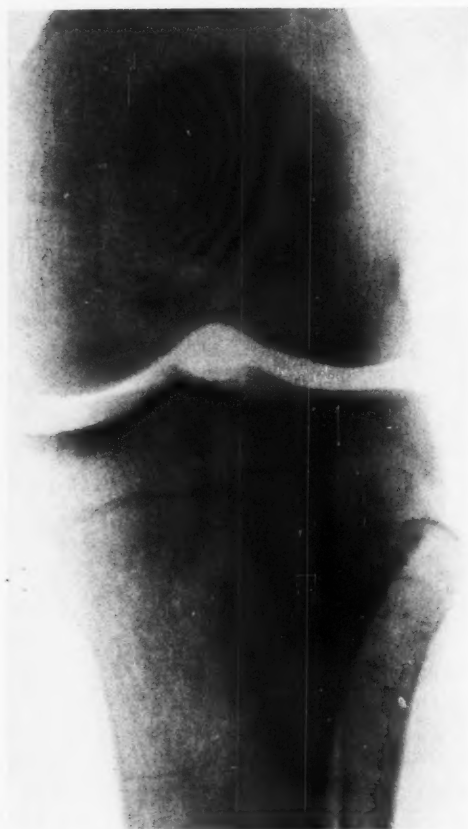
Osteogenic sarcoma of tibia treated with x-rays for three months; no improvement. Amputation by Dr. B. L. Coley, July 20, 1927. Pulmonary metastasis; death.
